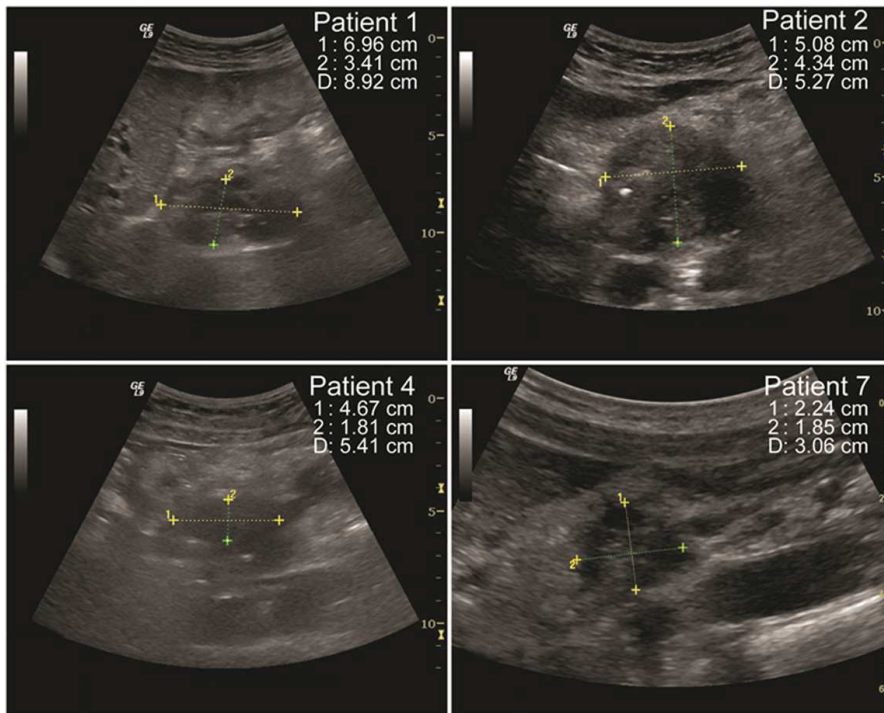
Representative ultrasound images showing the PDAC tumour in four of the ultrasound and microbubble treated patients. Tumour height and width are indicated by the yellow and green dotted lines. The ultrasound transducer was positioned to ensure no obstructions of the acoustical beam path to the tumour. This resulted in a unique ultrasound probe position per patient and treatment. Distance 1 and 2 indicate the tumour width and height respectively. Value D indicated the tumour centroid depth.
